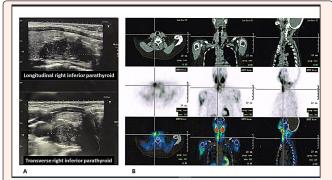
(A): Ultrasound of the neck where the lower right parathyroid gland is observed. 2(B): Mibi scintigram with Spect-CT shows right lower parathyroid uptake.
